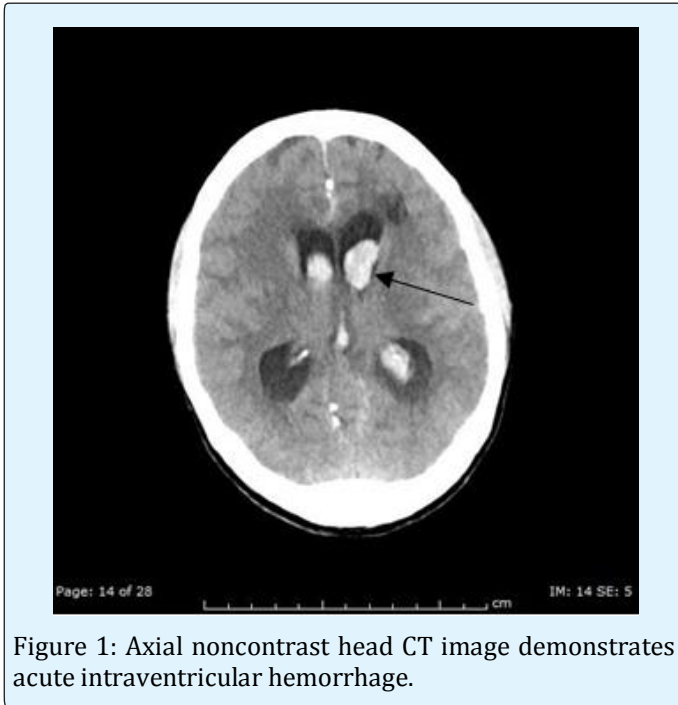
Axial noncontrast head CT image demonstrates acute intraventricular hemorrhage.
